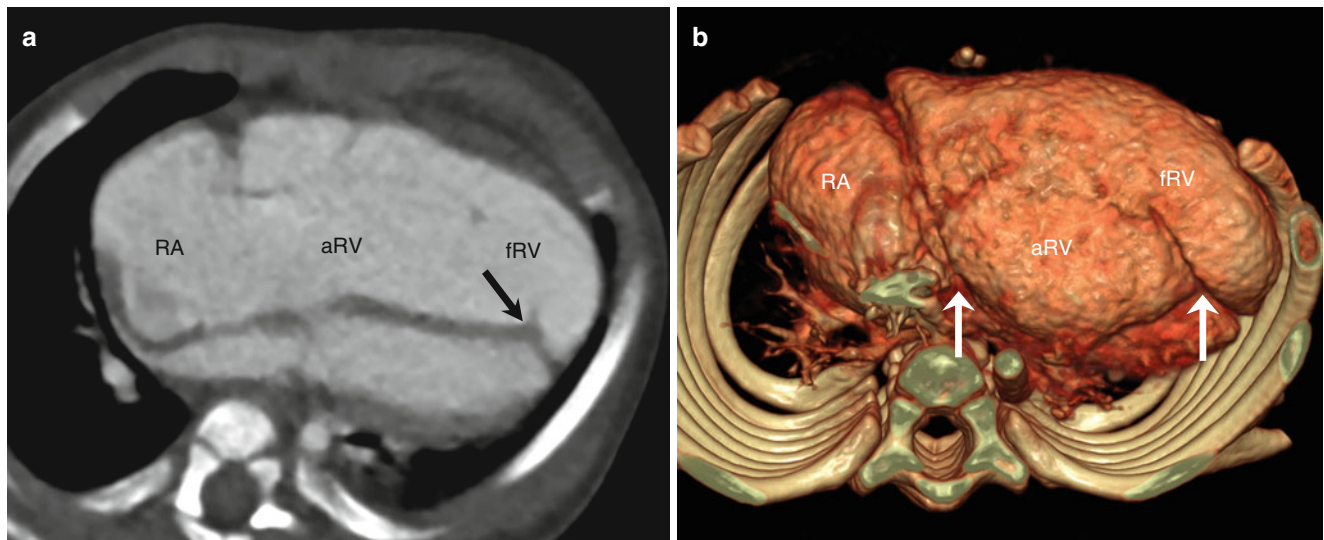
Ebstein anomaly. Four-chamber CT image shows a diagnostic finding of the apically displaced septal attachment (*arrow*) of the tricuspid valve that divides the right ventricle into the atrialized (*aRV*) and functioning (*fRV*) portions of the right ventricle (a). The right
